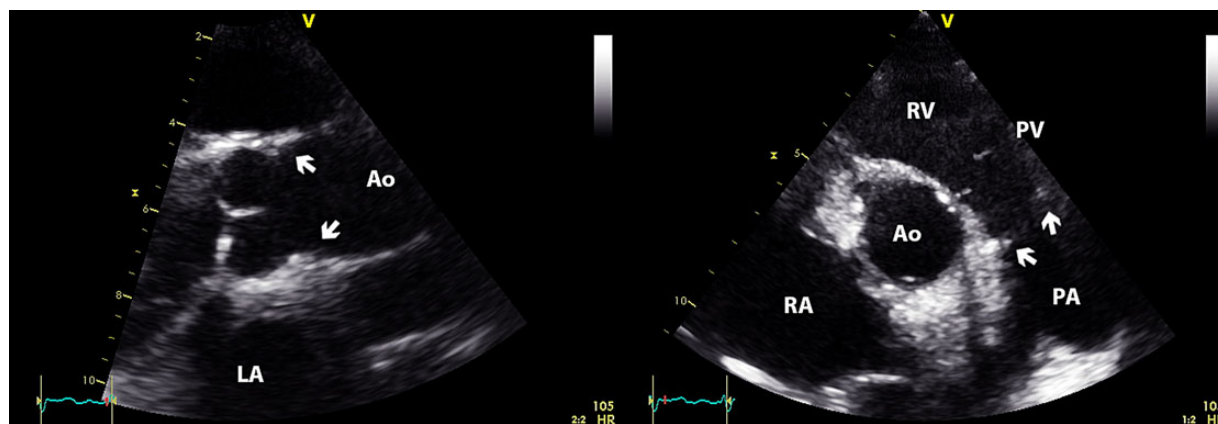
Two-dimensional echocardiography acquisitions focused on the ascending aorta and on the pulmonary artery. The suture lines could be easily identified. Arrow, suture lines; Ao, aorta; LA, left atrium; PA, pulmonary artery; PV, pulmonary valve; RA, right atrium; RV, right ventricle.
